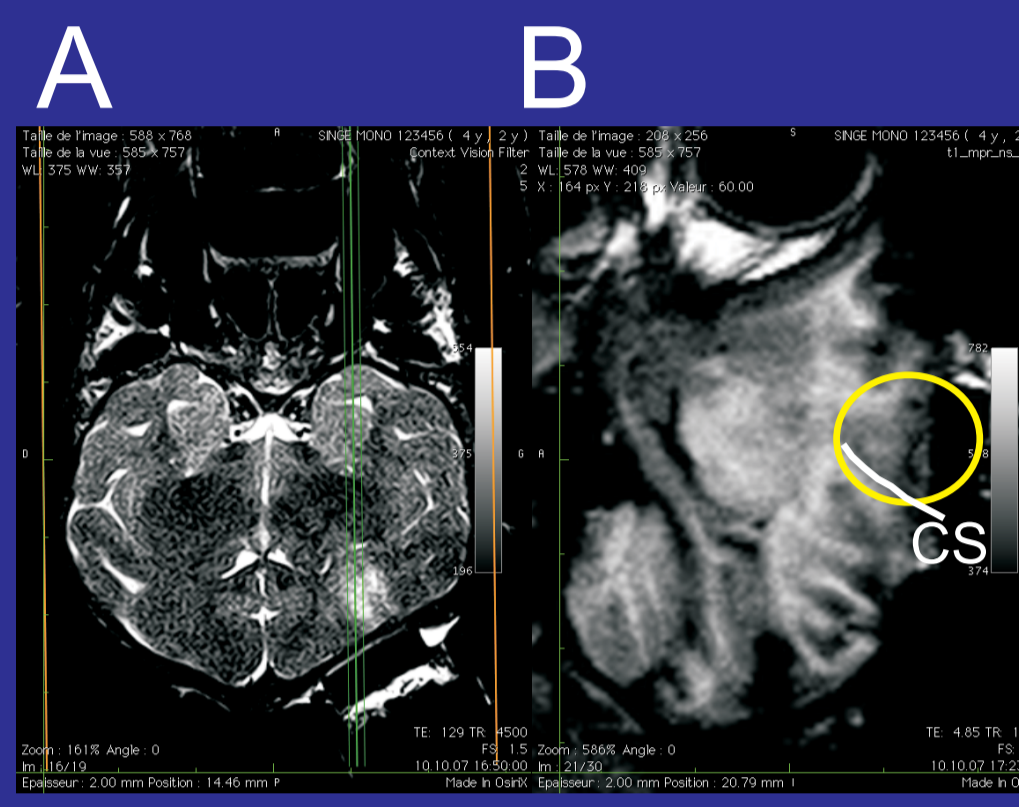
MRI showing the localisation of the lesion in Mk-AM and its corresponding location on the parasagittal axis. B: Lesion: yellow circle. CS: central sulcus
